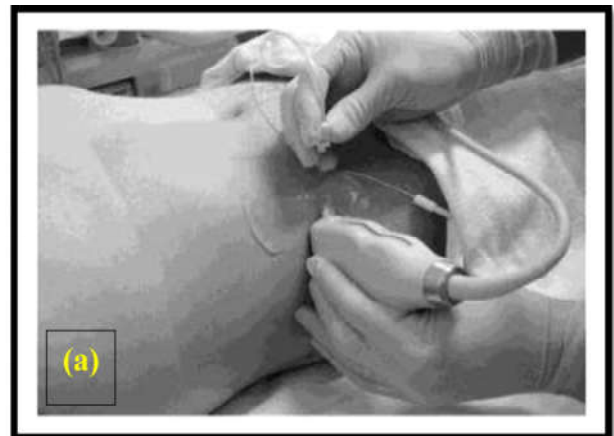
(a, b, c), Ultrasound-Guided TAP Block
